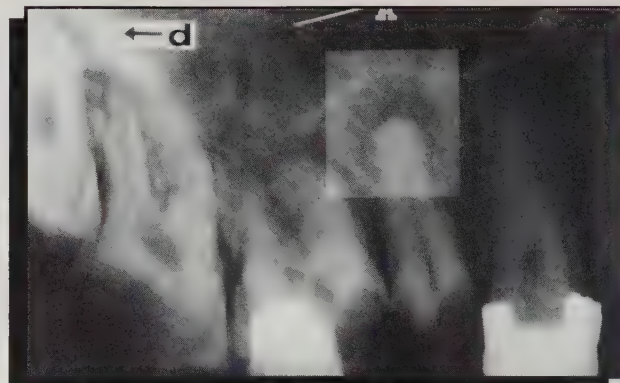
The letter "A" and the accompanying line to tooth 26 were obtained using the digital imaging software program and inserted into the radiograph, while the letter "d" and the accompanying arrow are actually external "Letraset" characters that were scanned into the computer system prior to their insertion into the radiograph.
